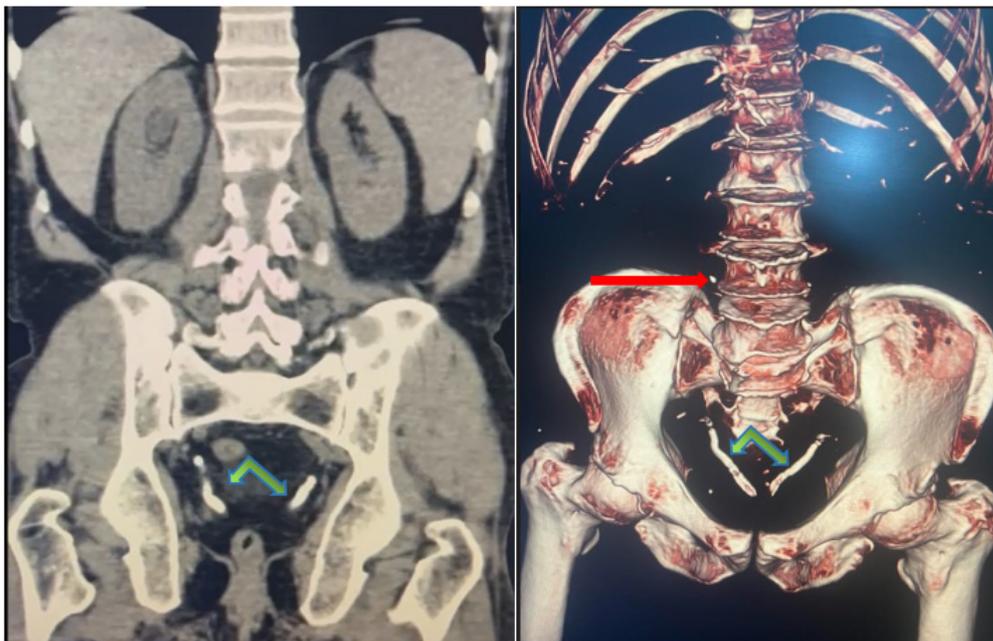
CT KUB (A) with 3D reconstruction (B) showing bilateral symmetrical vas deferens calcification (green arrow) with right upper ureteric calculus seen in 3D image (red arrow).
